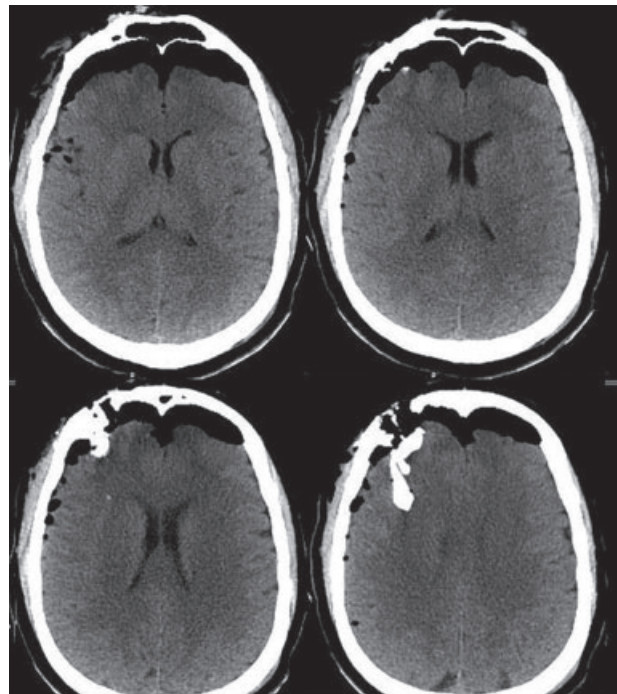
CT scan of the brain showing compound depressed fracture of the right frontal bone, in driven bone fragments and pneumocephalus.
